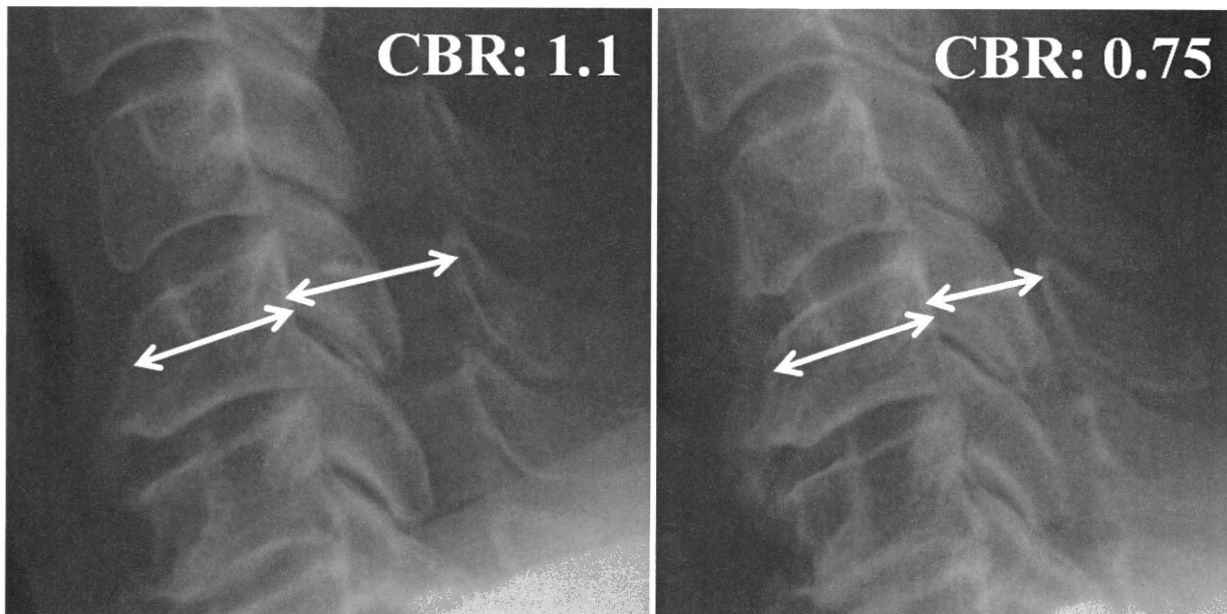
Representative radiographs of lamina closure. A 32% decrease in CBR from the image obtained immediately after surgery (*left*) to the final follow-up image (*right*) is shown, indicating the presence of lamina closure.
